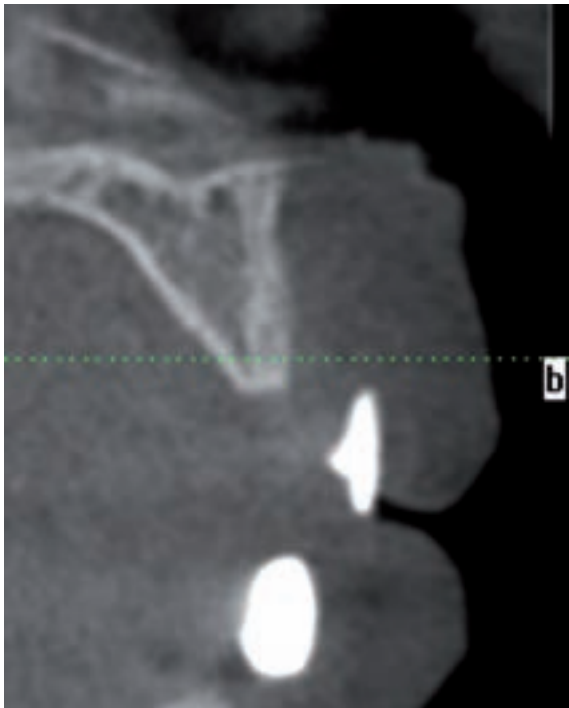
CT scan with radiographic template revealing the relationship between the residual ridge and planned prosthetic tooth position.
